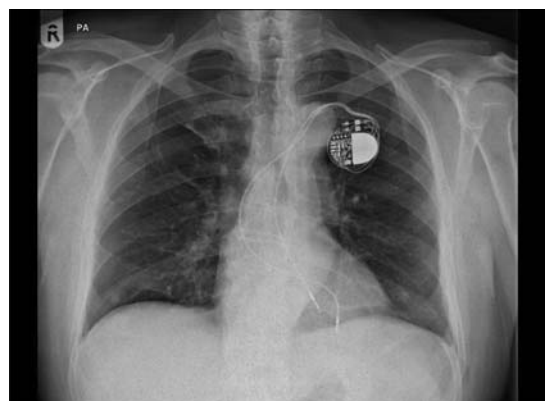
Chest radiograph demonstrating malpositioned pacing leads.
